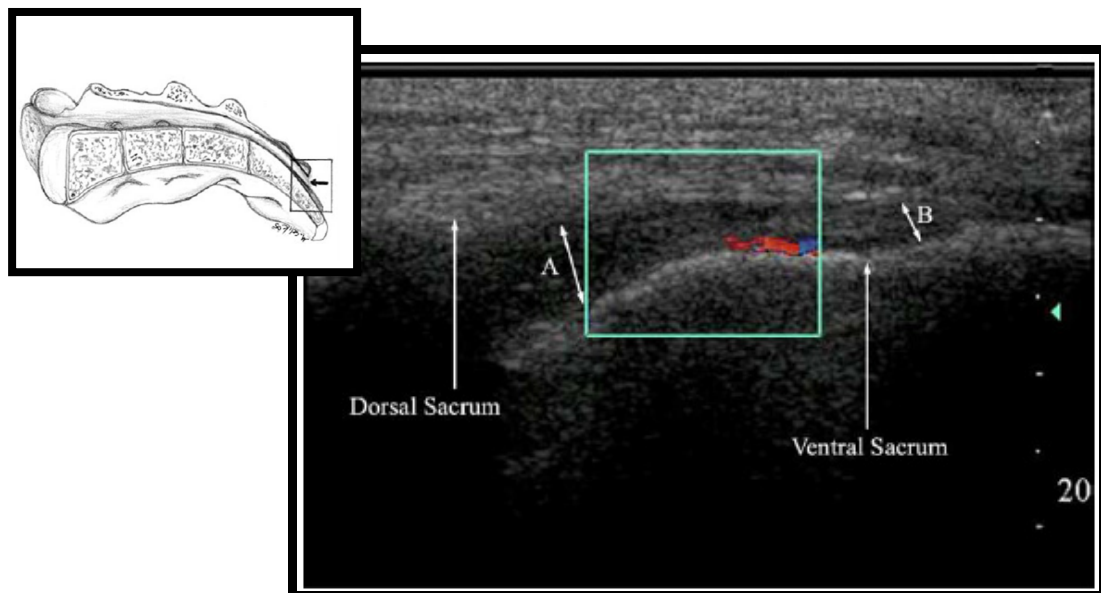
Colour Doppler ultrasonography, midsagittal view of the sacrum.
